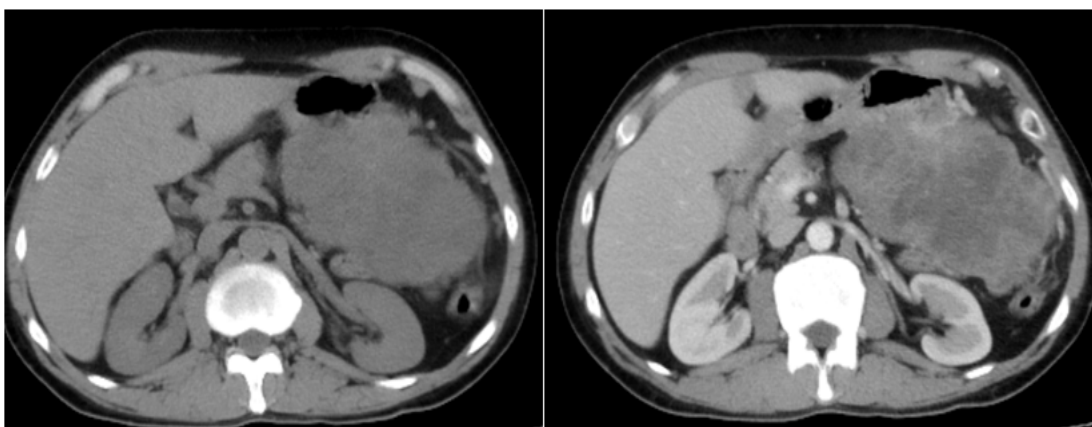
Abdominal CT scan showing a heterogeneously hypo dense exophytic 11*11*9cm mass arising from the body of the stomach, it shows heterogeneous enhancement with hypo enhancing central areas.
